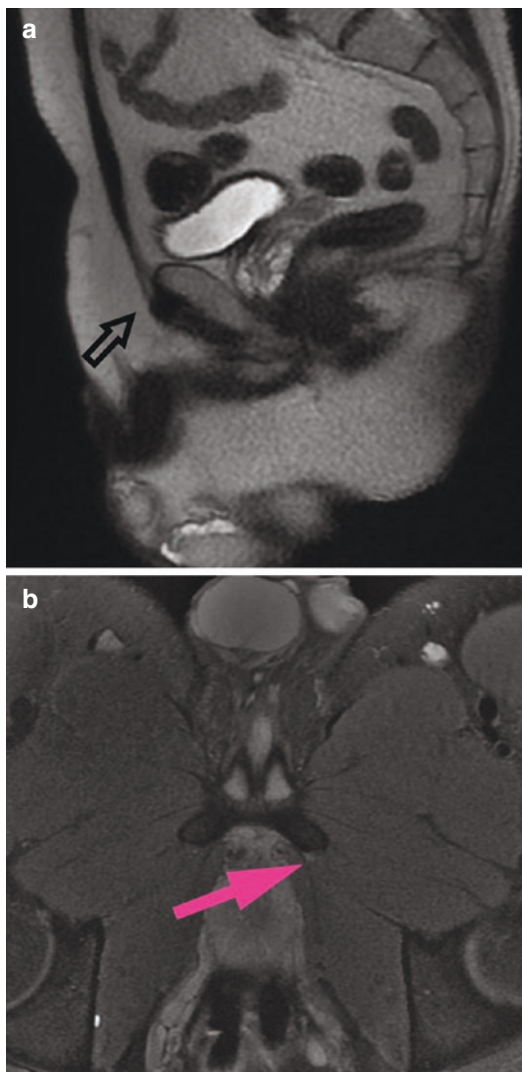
MRI of (a) rectus abdominis injury (arrow) and (b) adductor aponeurosis injury (arrow)
